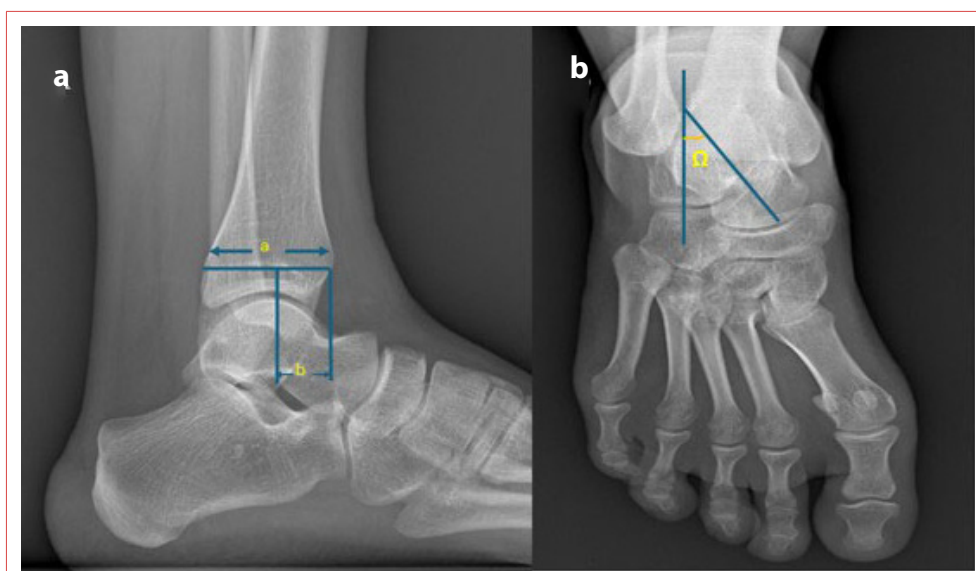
Additional radiographic measurements of ankle and hindfoot morphology. (a) Measurement of fibular position (FP). a represents the total anterior–posterior tibial depth and b represents the posterior displacement of the distal fibula; FP was calculated as $(b/a) \times 100$. (b) Measurement of the talocalcaneal angle (TCaA) on the dorsoplantar foot radiograph, with Ω representing the angle between the longitudinal axes of the talus and calcaneus.
